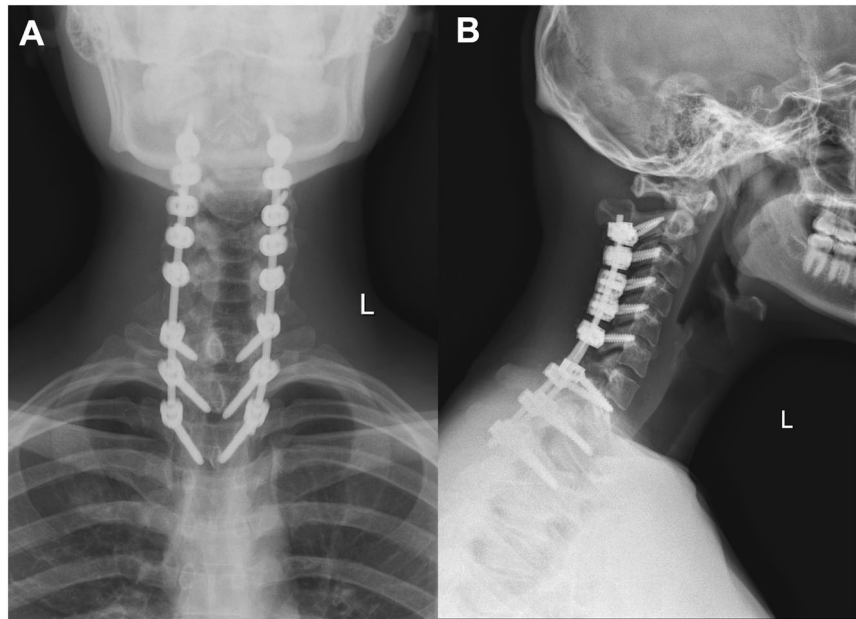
Postoperative scoliosis radiographs. Caption: Standing anteroposterior (A) and lateral (B) scoliosis radiographs on postoperative day 4.
